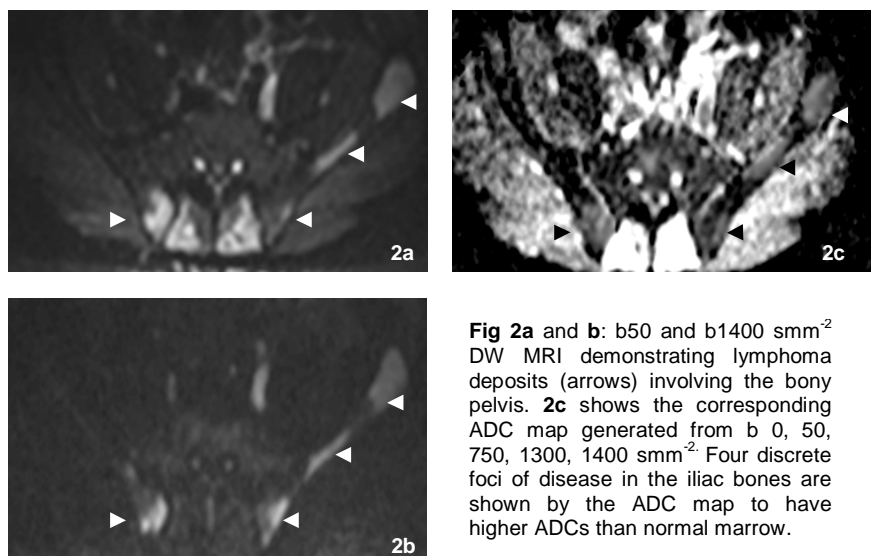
b50 and b1400 mm^2 DW MRI demonstrating lymphoma deposits (arrows) involving the bony pelvis. 2c shows the corresponding ADC map generated from b 0, 50, 750, 1300, 1400 mm^2 . Four discrete foci of disease in the iliac bones are shown by the ADC map to have higher ADCs than normal marrow.
